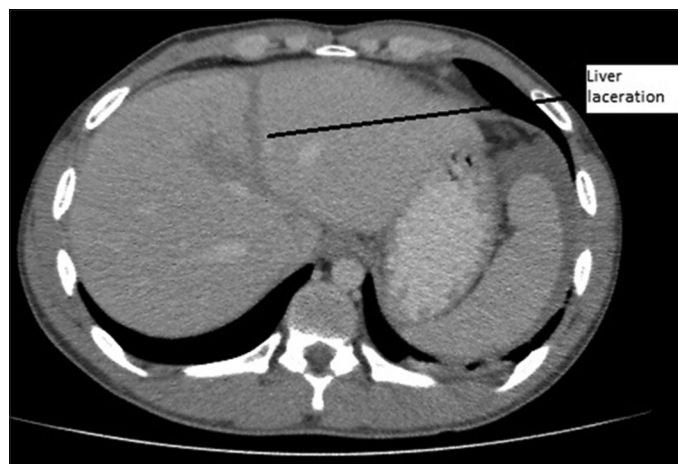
Computed tomography scan image showing liver laceration in portal phase axial section
